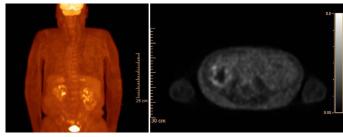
PET CT revealed a right renal mass with hypermetabolism up to SUV 3.3 suspicious for RCC.
